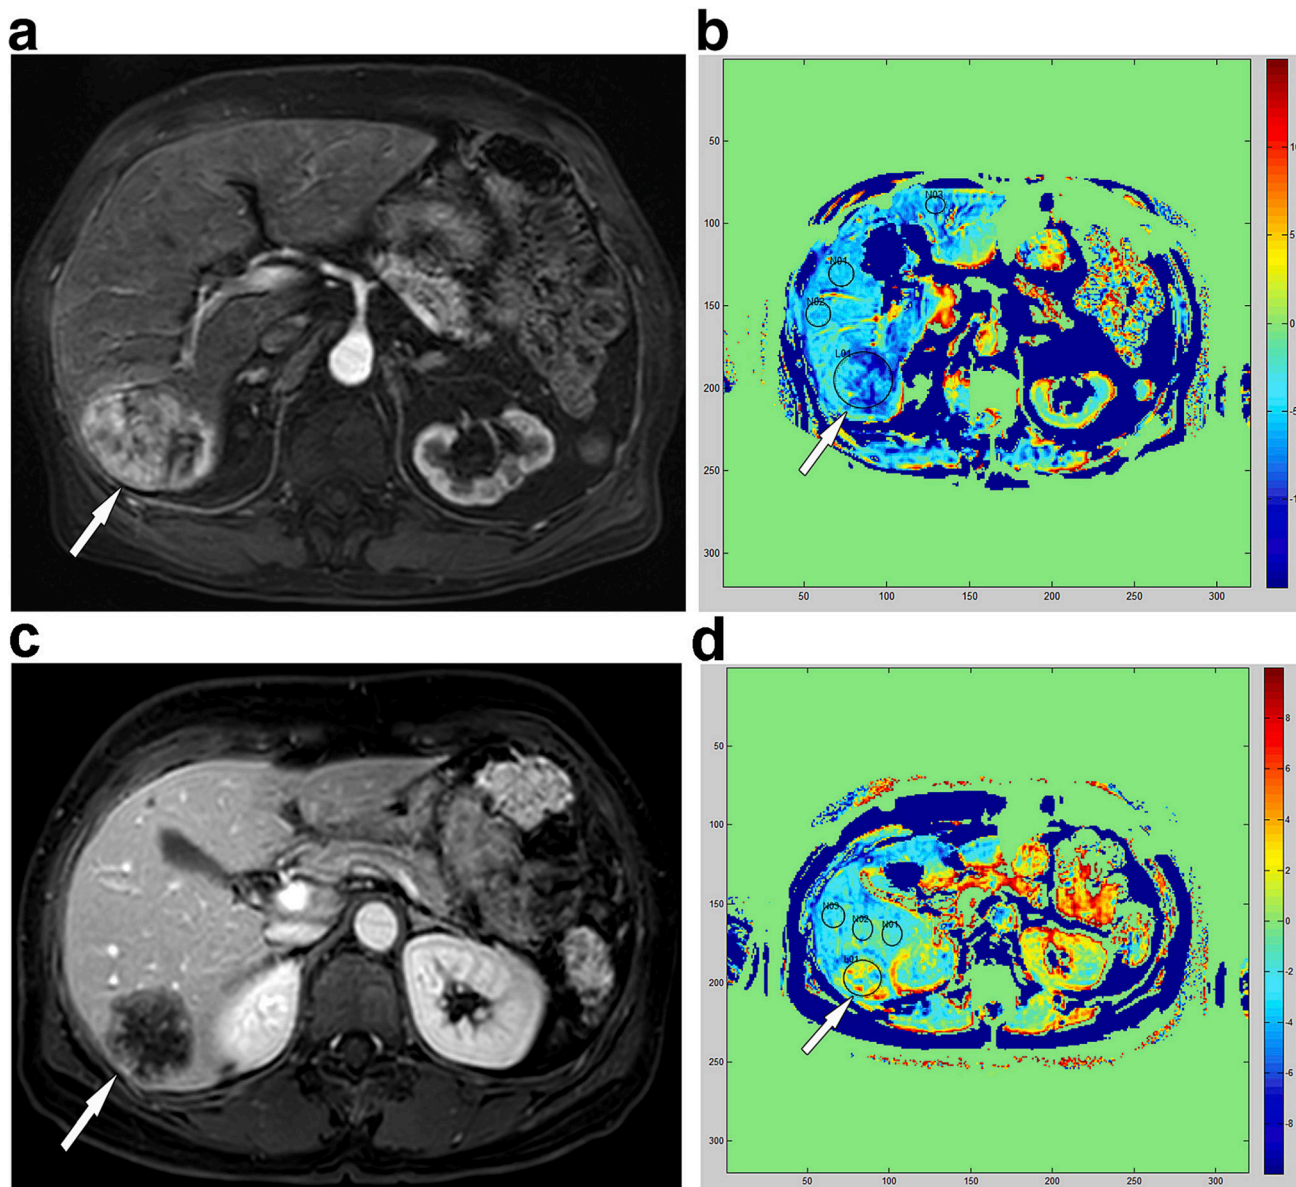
Amide proton transfer weighted (APT_w) imaging in a 78-year-old man with a hepatocellular carcinoma (HCC) and in a 61-year-old woman with hepatic metastases from colon cancer. a: Contrast-enhanced T1-weighted image obtained during the late arterial phase shows a 6.6-cm HCC (arrow) in the liver segment 6. b: On the corresponding APT_w map, the magnetization transfer ratio asymmetry (MTR_{asym}) values of HCC and the background liver were -7.23% and -5.42% , respectively. c: Contrast-enhanced T1-weighted image obtained during the portal venous phase shows a 4.2-cm metastasis (arrow) in the liver segment 6. d: The corresponding APT_w map shows an elevated MTR_{asym} value for metastasis (0.42%) than the averaged MTR_{asym} of three region of interests in the background liver (-1.98%). Reproduced with permission from Seo et al., Eur Radiol 2020; 31: 222–231.
